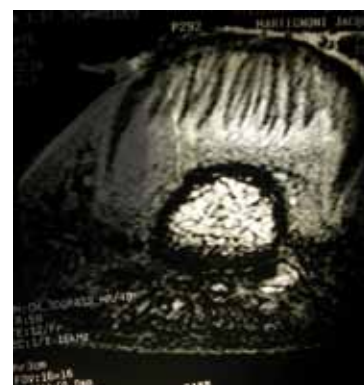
Digitations of the tumor are visible on MRI in transverse and sagittal sections.
